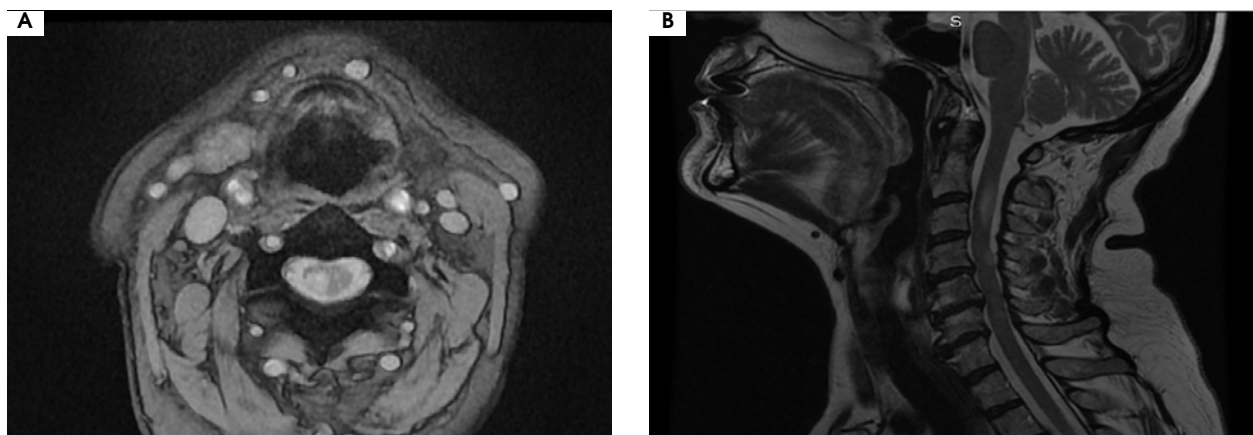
Hyperintense lesions in C1-C4 cervical segments in cervical magnetic resonance imaging T2 sequence
